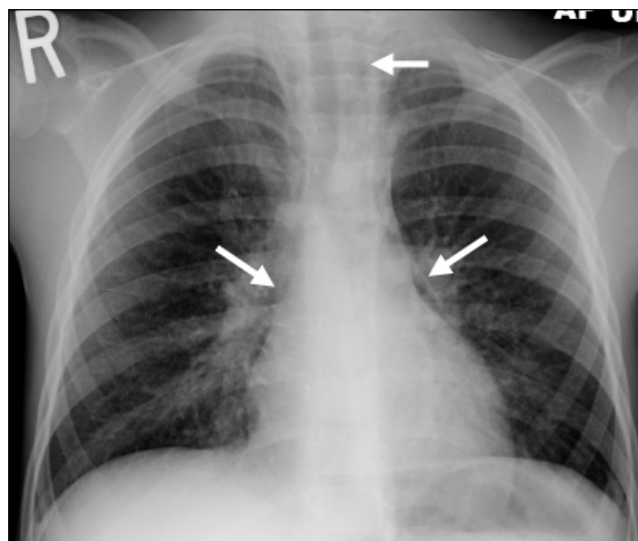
Presenting AP Upright chest radiograph demonstrating lucency tracking along the lateral heart borders bilaterally and into the cervical soft tissues.
